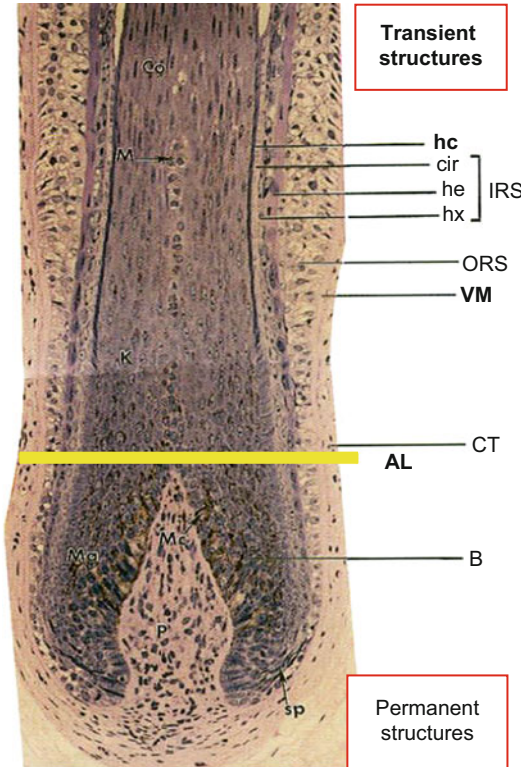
Lower part of the follicle. In the bulb (*B*), the undifferentiated matrix cells (*Ma*) are arranged in a line as they ascend toward the keratogenous area (*K*) where the cortical cells (*Co*) are keratinized. The bulb contains the dermal papilla (*P*). Immediately above the matrix cells, a line known as Auber’s line (*AL*) separates the permanent structures of transitory structures. The melanocytes (*Mc*) are arranged on the roof of the dermal papilla. Hair is composed by medullar cells located in the center. Note that the medulla is discontinuous. Surrounded the medulla are the hair cortex and epidermicule or hair cuticle (*hc*). The outer (*ORS*) and inner root sheath (*IRS*) with their three different layers (Henle’s layer (*he*), Huxley’s layer (*hx*), and the cuticle of the inner root sheath (*cir*)) can be followed easily until the level of the bulb, where they are separated by dark spinous cells (*sp*) that are the cells of the companion’s layer. The connective tissue sheath (*CT*) is continued with the dermal papilla and is separated by a thick vitreous membrane (*VM*) which in its internal part can be confused with the basal membrane
